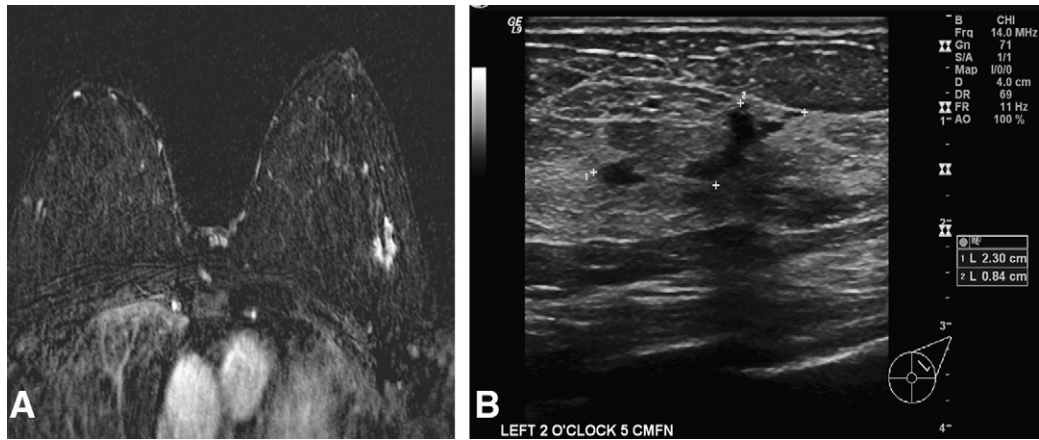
(A) Postcontrast axial T1-weighted magnetic resonance image (MRI), showing an abnormal enhancing lesion located within the left upper outer quadrant. A 54-year-old patient found to have metastatic adenocarcinoma that involved the left axillary node of unknown origin. Mammogram and ultrasound (US) were obtained first and revealed no abnormalities. (B) Anti-radian sonographic image of a second-look US, showing a crescent-shape hypoechoic area in the region that correlates to the MRI finding. Pathology revealed invasive ductal carcinoma, not otherwise specified.
